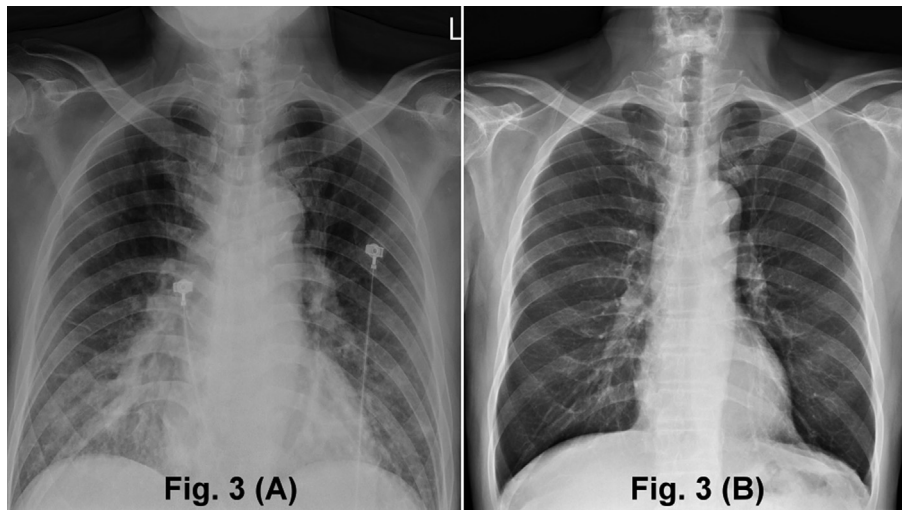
Case 3: chest radiograph showing features of bilateral interstitial edema at presentation (A) and resolution of pulmonary edema after treatment with nitroglycerin and hemodialysis (B).
